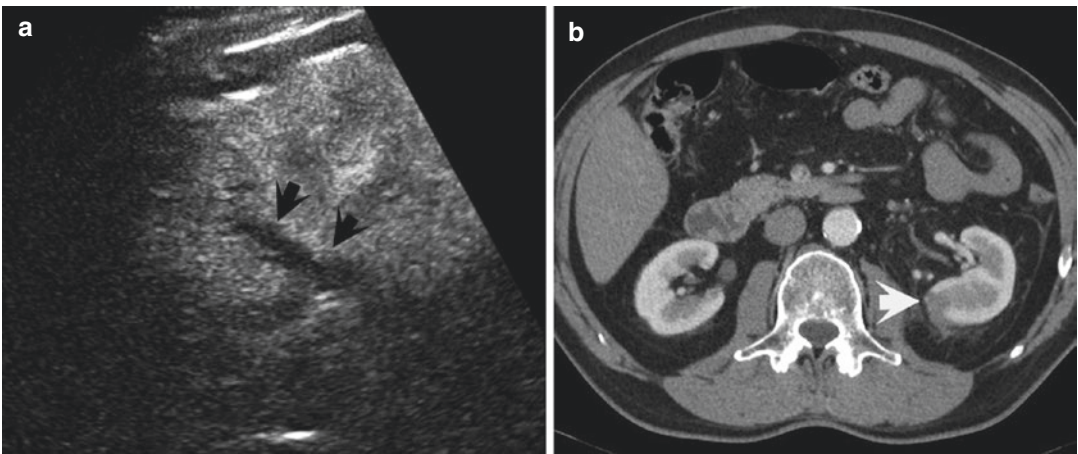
Renal trauma with fracture of the posterior labrum (*black arrows*) (a) confirmed at CT (*white arrow*) (b)
